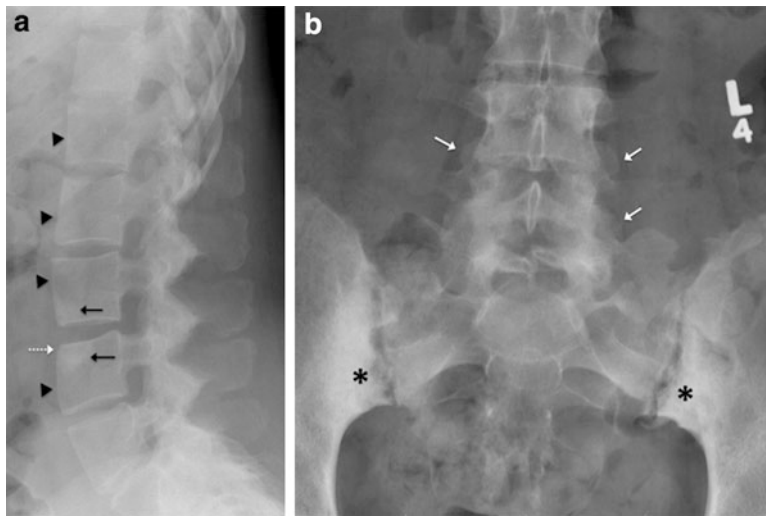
(a) Lateral radiograph of the lumbar spine demonstrates squaring of the vertebral bodies (arrowheads). The irregularity and erosion at the anterior edge of the endplates, known as Romanus lesions (dashed white arrow), are early findings in inflammatory spondyloarthropathies such as ankylosing spondylitis. The “shiny corners” in the anterior aspects of the endplates (black
